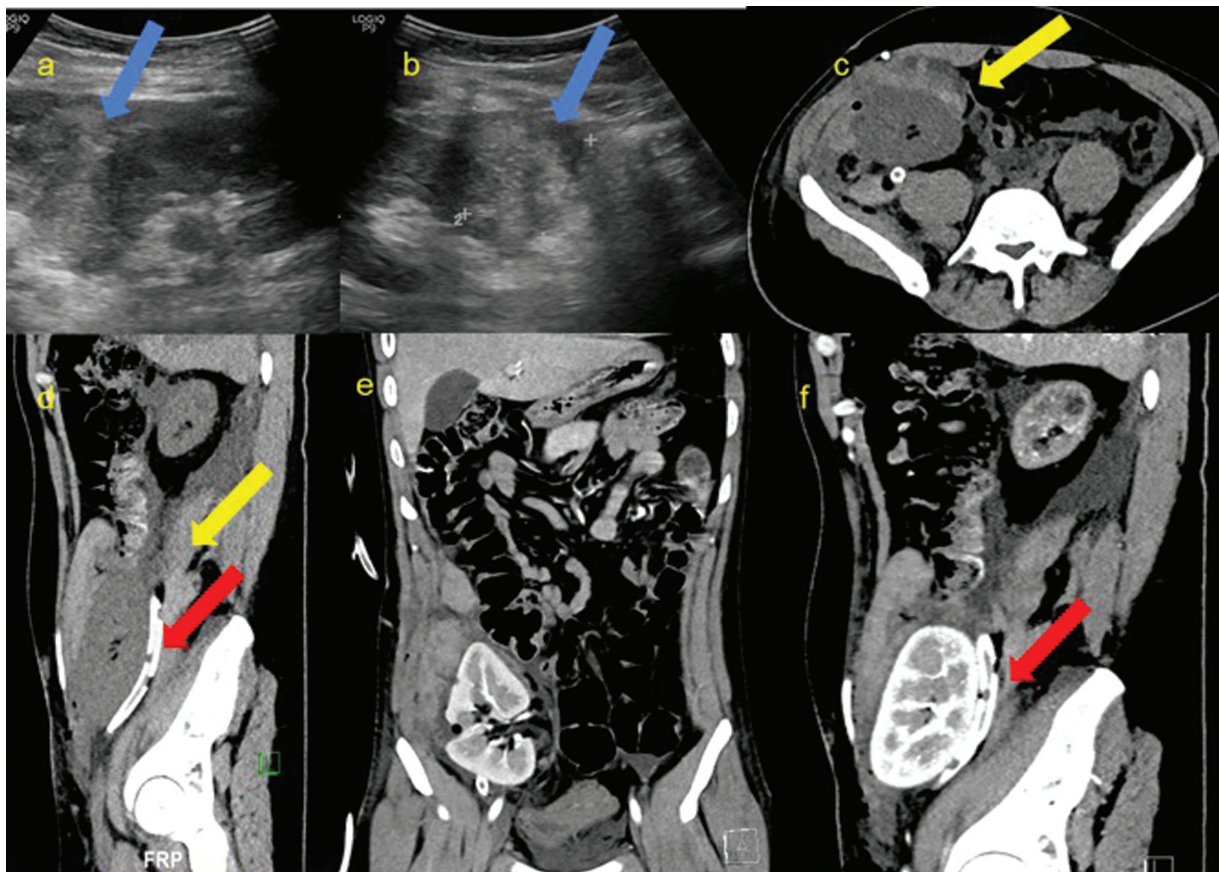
Images of a 28-year-old male patient (posttransplantation, second postoperative day) presented with abdominal pain and a drop in hemoglobin. Ultrasound images (a and b) show hyperechoic focus (blue arrows) adjacent to the transplanted kidney. Noncontrast CT images (c and d) show large perinephric hematoma (yellow arrows) with the extension of hematoma cranially on both anterior and posterior aspects. In addition, the drain (red arrows) was seen along the posterior surface of the transplanted kidney. There was no active contrast extravasation in contrast-enhanced CT images in coronal and sagittal sections (e and f). The patient was managed conservatively. CT, computed tomography.
